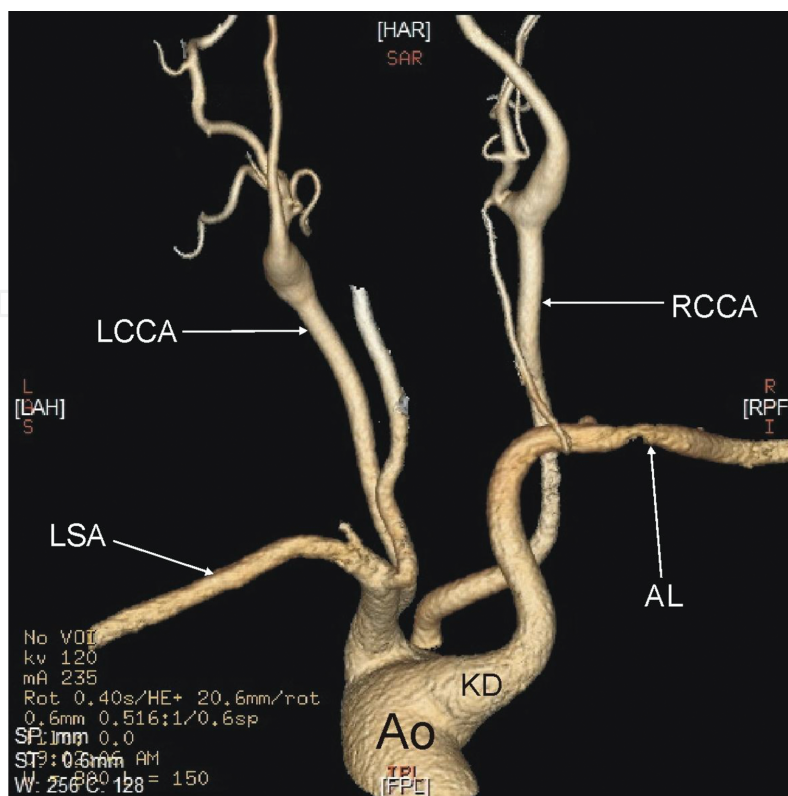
Three-dimensional computed tomography reconstruction of the arteries (CT-64-row MDCT scanner, Light-Speed VCT, GE, Waukesha, Wisconsin, USA). Ao—arch of the aorta, AL—arteria lusoria, KD—Kommerell's diverticulum, LSA—left subclavian artery, LCCA—left common carotid artery, RCCA—right common carotid artery.
